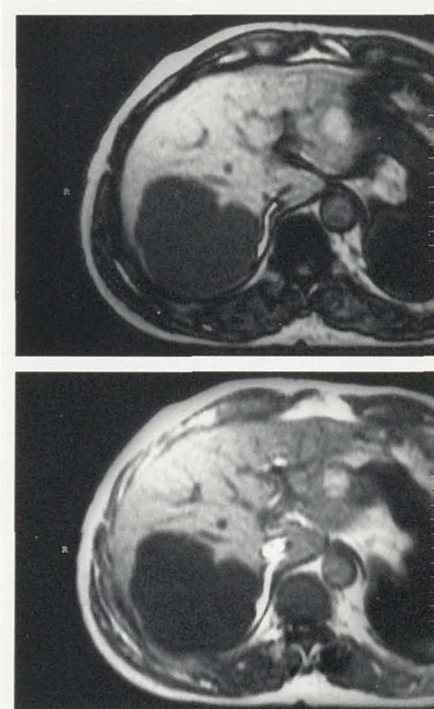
Hepatic cavernous hemangioma. (a) Opposed-phase T1-weighted FLASH image shows a hypointense hepatic mass corresponding to a hemangioma. The mass shows the same signal intensity on in-phase image (b) which indicates the mass is composed entirely of water.
